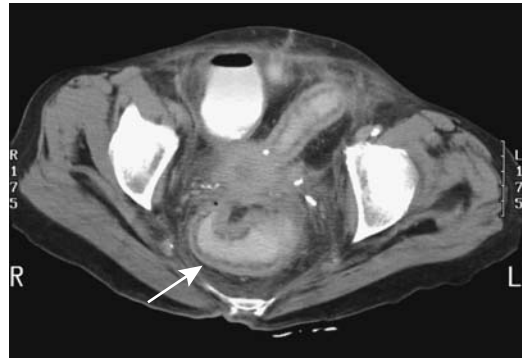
Clostridium difficile* colitis. CT reveals circumferential colonic and rectal wall thickening (arrow). (Courtesy of Patrick Fultz, M.D., University of Rochester.)
